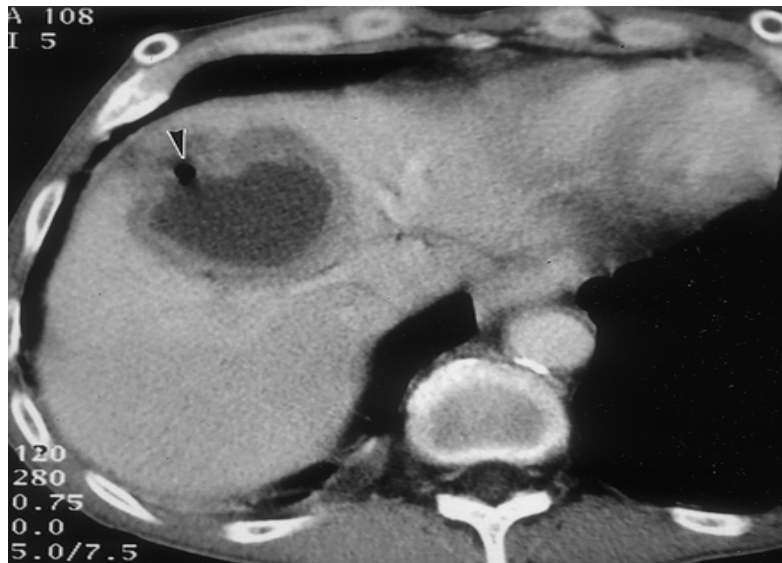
B Contrast-enhanced CT scan shows a thick-walled cystic lesion with peripheral enhancement. Note the small pocket of air in the nondependent portion of the mass (arrowhead), which is virtually a pyogenic liver abscess.
